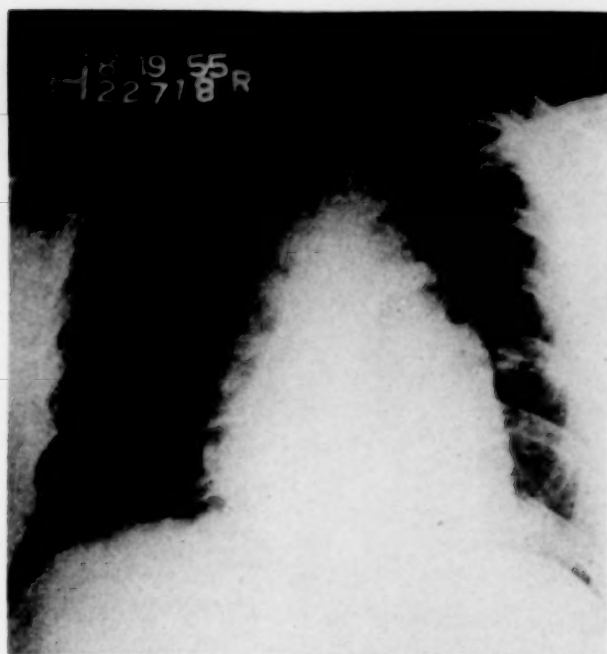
X-ray of the chest prior to final courses of radiation therapy, Case iv.
